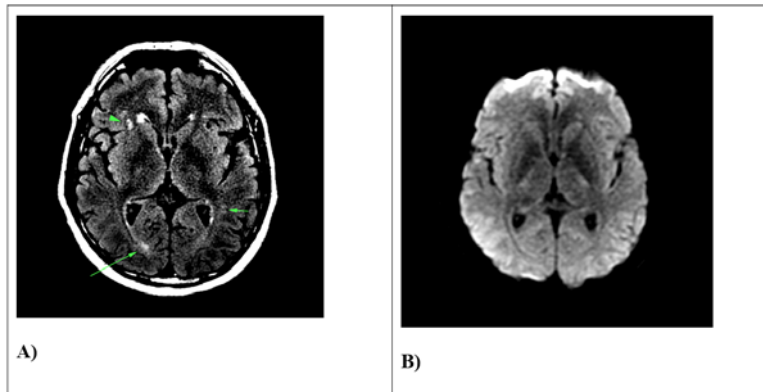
A and B. Brain MRI: A/FLAIR T2 sequence; B/DWI sequence, axial plane.
